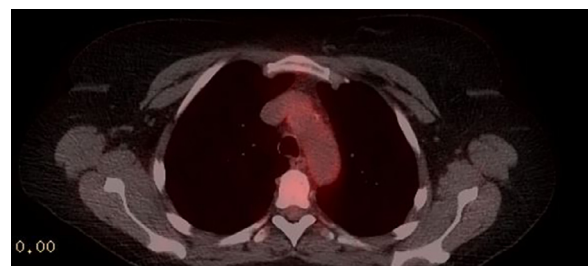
Axial section of a PET CT demonstrating FDG-uptake consistent with aortitis.
